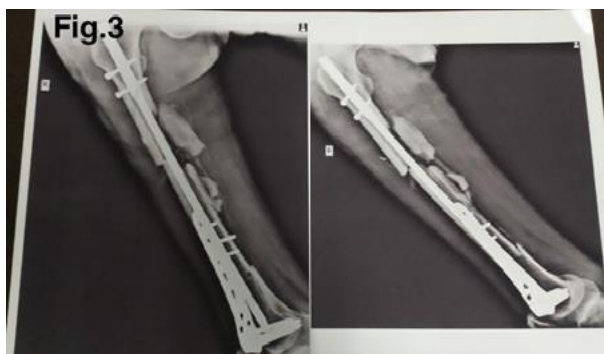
shows an X-ray produced on January 10, 2020, just after surgery
